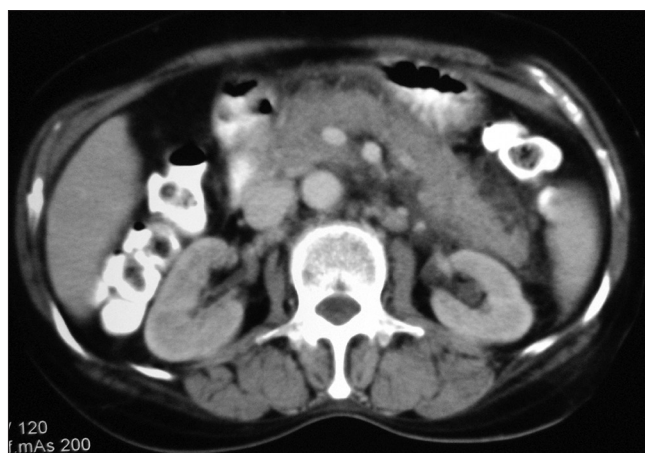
Contrast-enhanced computed tomography of abdomen showing enlarged pancreas with peripancreatic stranding
